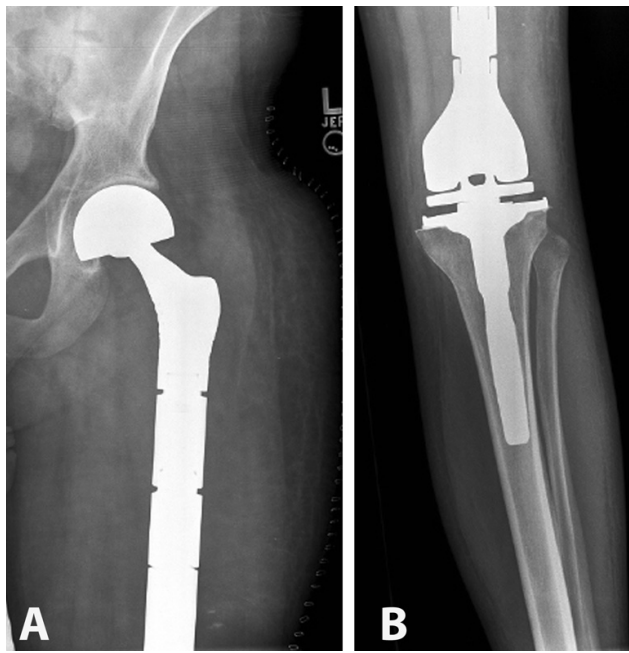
Postoperative AP radiographs of the hip (A) and knee (B) show total femur replacement with hemiarthroplasty.
